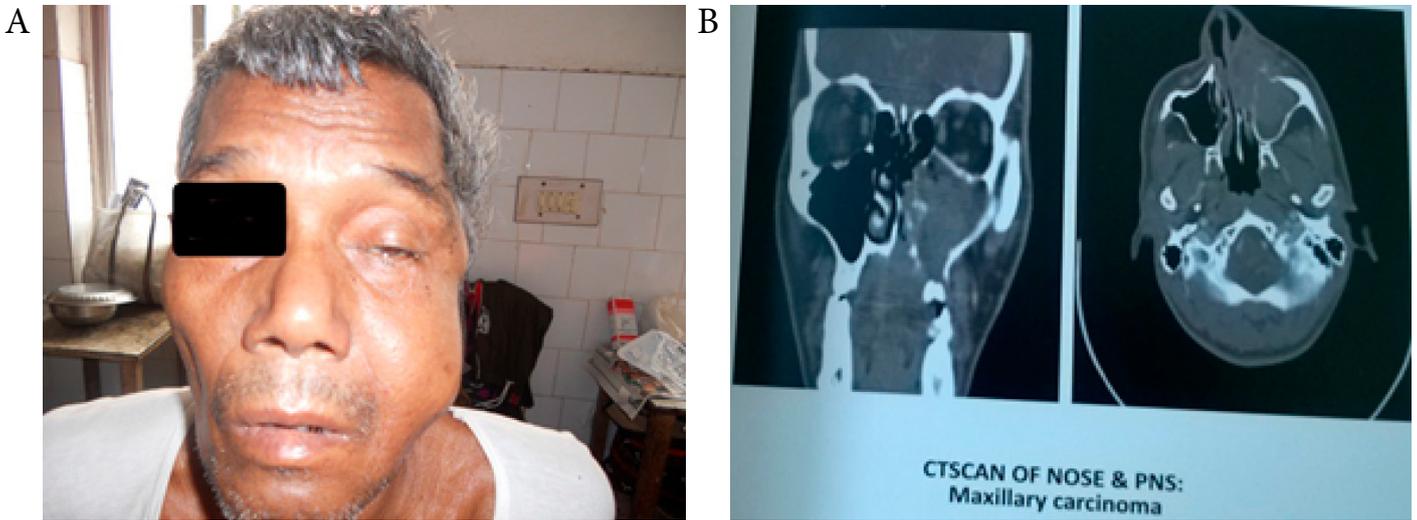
SCC [squamous cell carcinoma] of left maxilla. (A) Clinical picture; (B) CECT [contrast-enhanced computed tomography] suggestive of enhancing lesion occupying the entire left maxilla extending to nasal cavity with widening of OMC [ostiomeatal complex], bone thinning of the wall of maxilla with bone destruction of palate and extension into oral cavity. The other one is non-contrast axial image representing the same.
